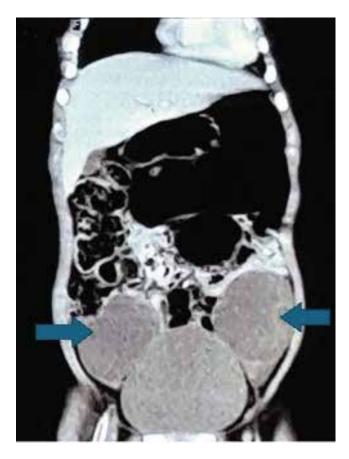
Computed tomography scan of abdomen with contrast, coronal view showing bilateral ovarian cyst
